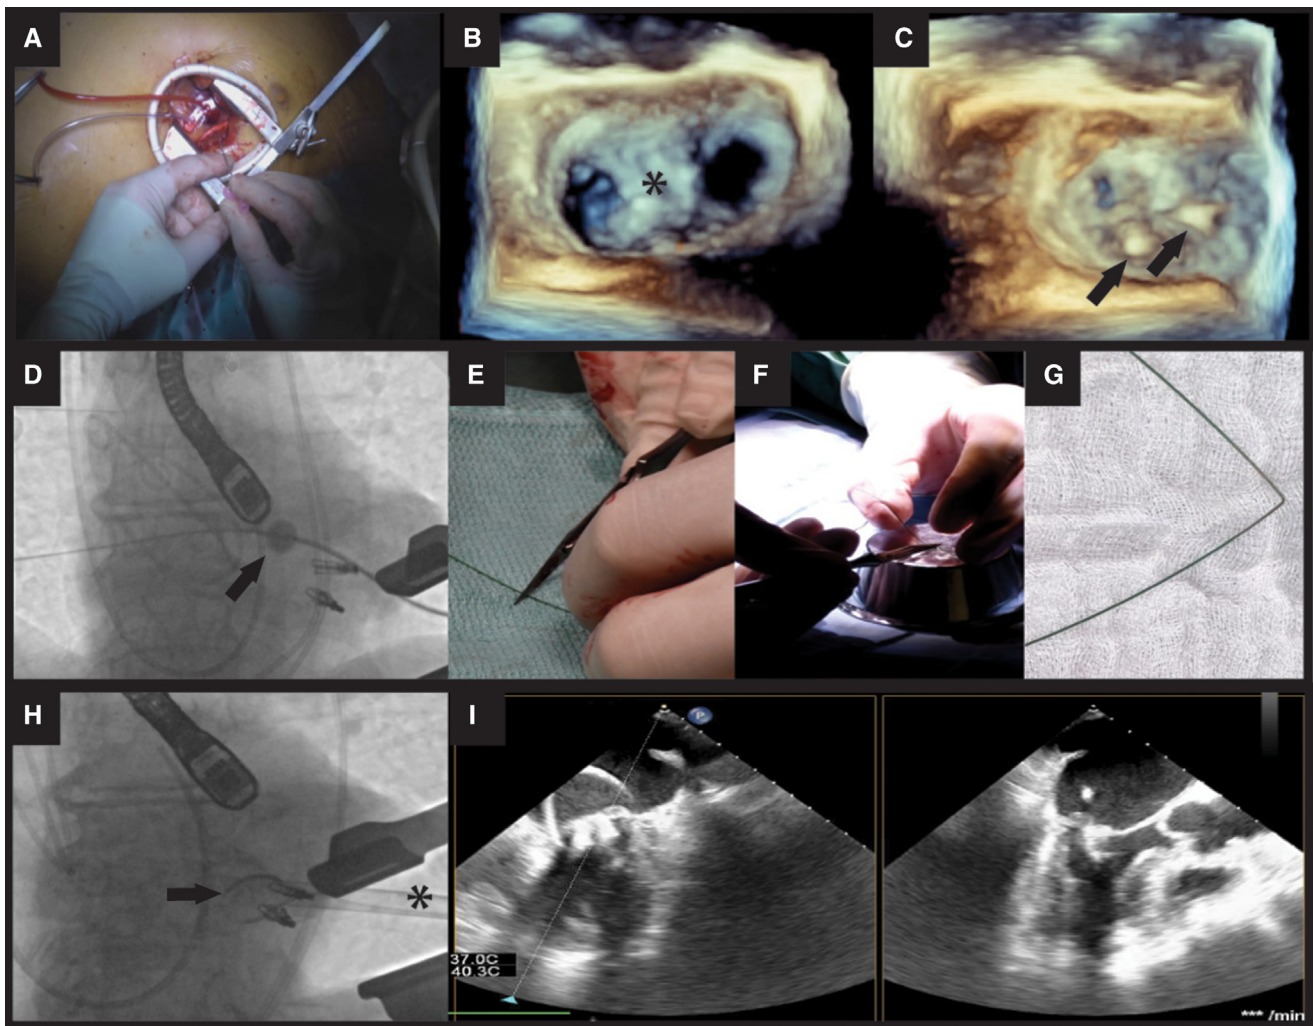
Procedural step 2 in vivo—the wire loop. The apex is punctured at the TMVR access site (A). The double-orifice mitral valve with 2 MitraClips (*asterisk*) in the middle segment (B) is crossed with 2 guidewires (*arrows*, C). A balloon wedge end-hole catheter (*arrow*) is used to confirm that there is no chordal entanglement (D). An Astato wire is denuded (E) and a V-shape is formed (F and G). The V (*arrow*) in between 2 isolating Berenstein catheters is positioned on the AML by steering the sheath (*asterisk*) anteriorly (H). The wire loop alignment can be visualized on x-plane transesophageal echo (I). TMVR, Transcatheter mitral valve replacement; AML, anterior mitral leaflet.
